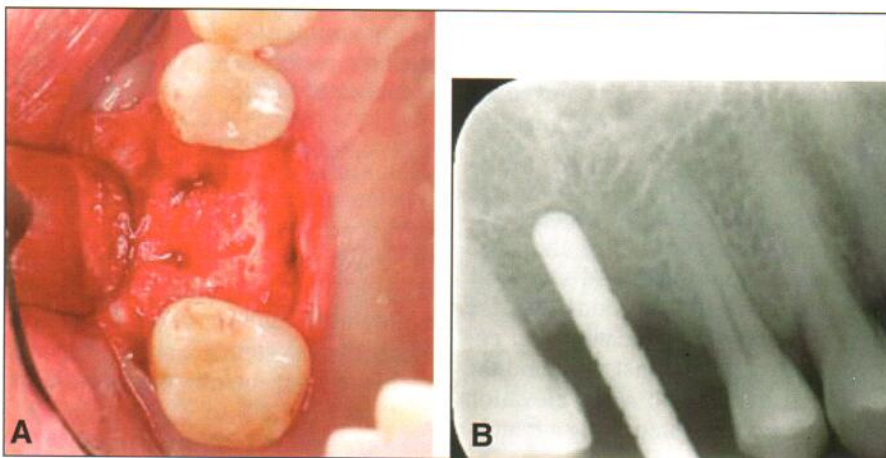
A, Full-thickness flap. B, radiographic guide pin showed that it was close to sinus floor.
